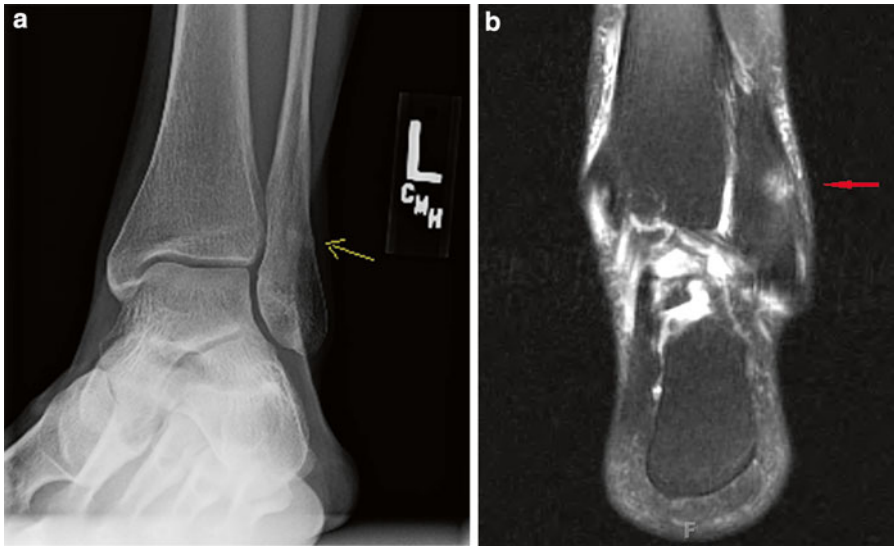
(a) Mortise ankle radiograph in a 35-year-old female recreational runner with 3 months of left ankle pain. The patient was diagnosed with a lateral malleolar stress fracture. Notice a cortical reaction is visible approximately
